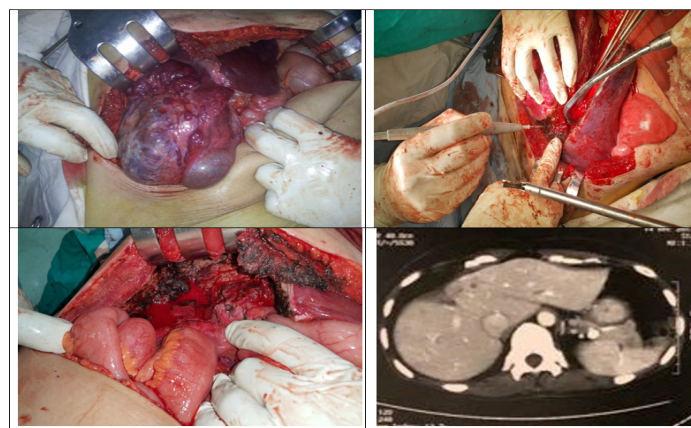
Female patient 45 yrs old with central haemangioma. A. Central haemangioma. B. During enucleation. C. Surgical bed. D. CT 2 yrs follow up.
